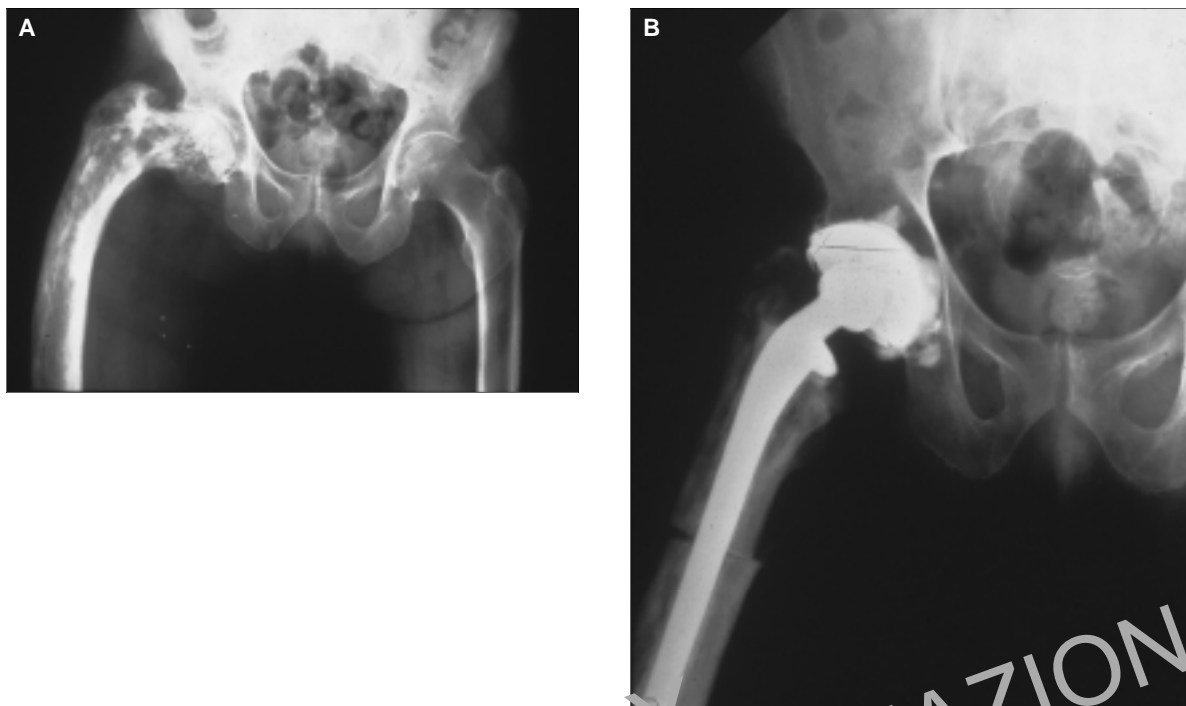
Anteroposterior radiograph of a patient with Paget's disease. The loss of normal trabecular pattern of the bone, widening of the canal, and the ensuing deformity is all apparent (A). Intraoperative osteotomy had to be performed to allow insertion of femoral prosthesis (B).
